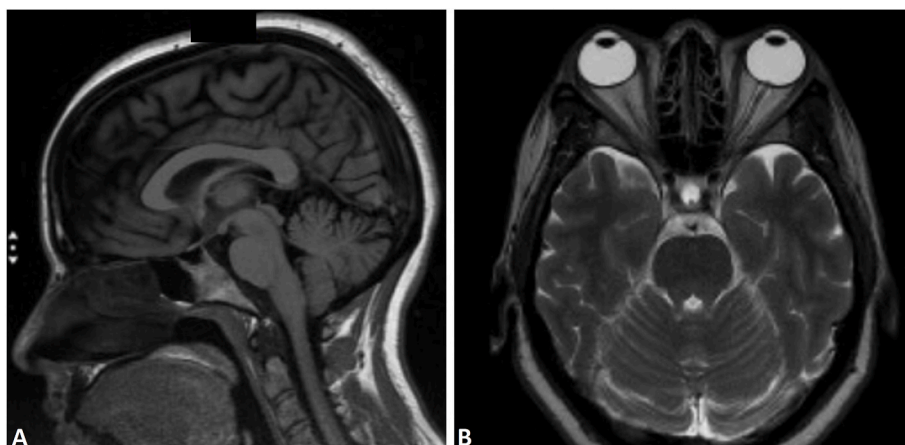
(A, B): A) T1 weighted scan in the sagittal plane demonstrating partial empty sellae due elevated intracranial pressure. B) T2 weighted MRI transverse of flattened posterior globes.
